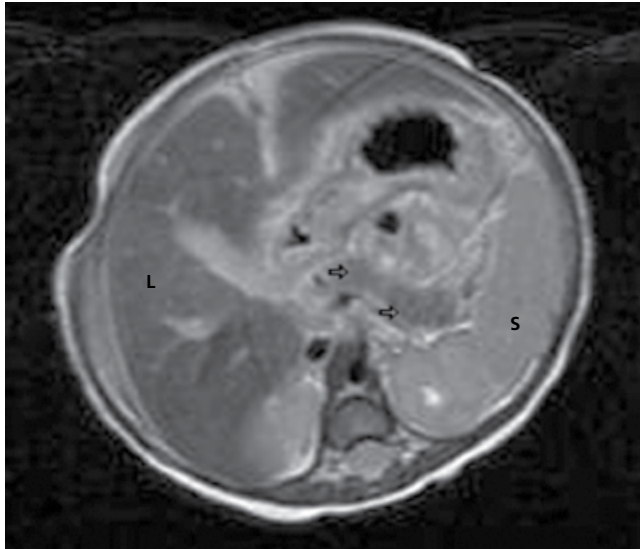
MRI showing extrahepatic siderosis in a term infant with liver failure. The T2-weighted series image shows liver (L) and pancreas (arrows) to be dark relative to spleen (S), indicating excess iron (siderosis) of these tissues. This along with liver failure established the diagnosis of neonatal hemochromatosis.
